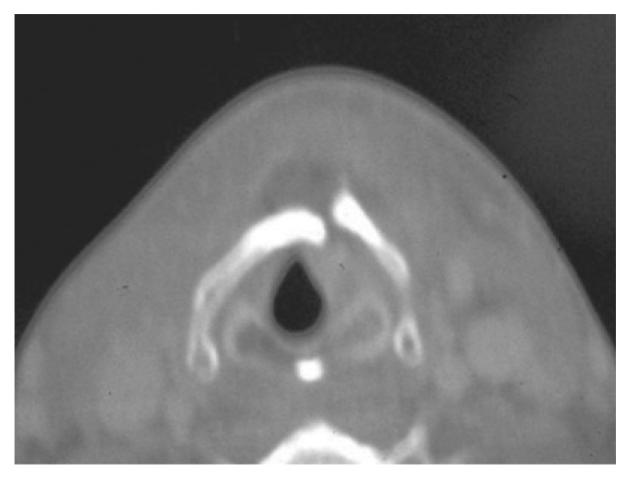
Computed tomography demonstrates a displaced cartilage fracture. The integrity of the mucosa should be confirmed endoscopically. The cartilage requires reduction and fixation.
